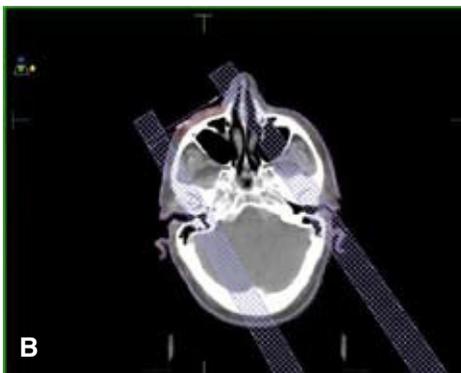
Conformal radiotherapy with 3-dimensional planning. A, Linear accelerator. B, C, D, definition of tumor volume (squamous cell carcinoma in right nasolabial crease) and critical organs (right retina and lens) on computed tomography scans. E, dose-volume histogram.
